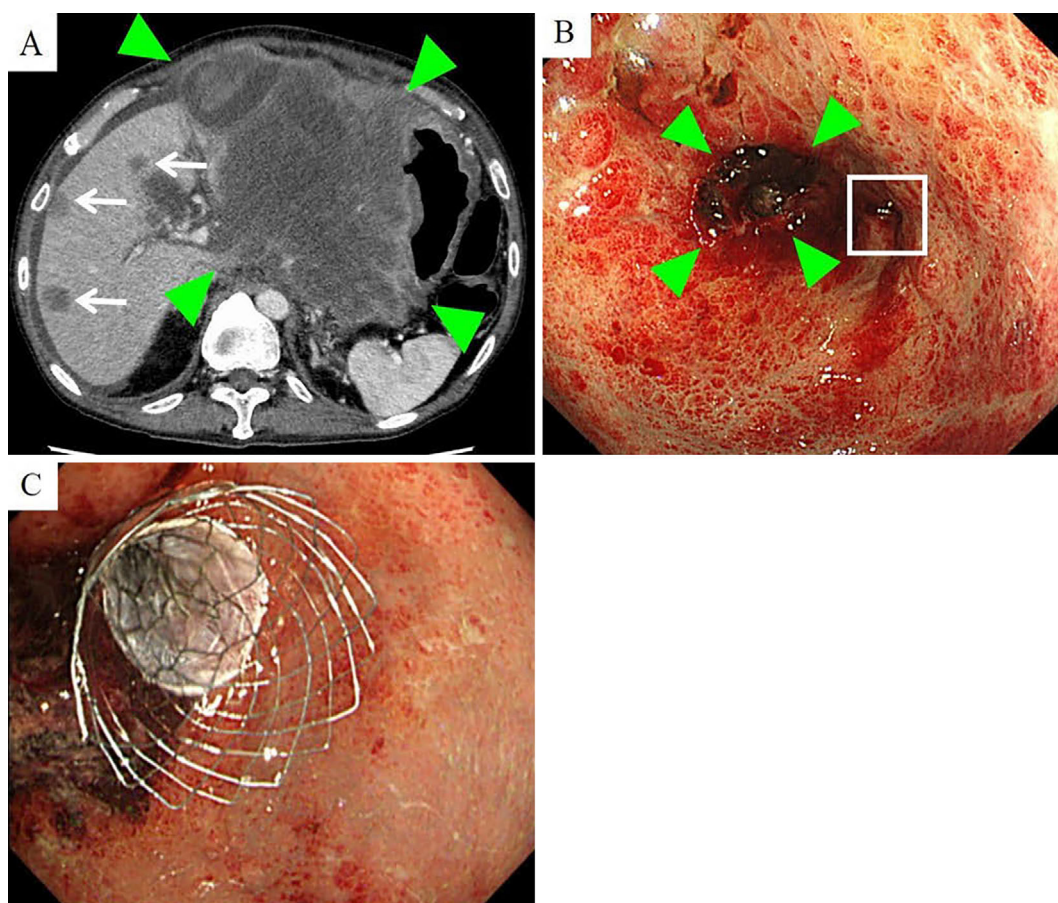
Contrast-enhanced computed tomography images at our hospital on day 56. The pancreatic tumor had grown quickly (arrowheads) and liver metastases were detected (A). Endoscopic examination on day 66 revealed gastric invasion and gastric outlet obstruction (B). A self-expanding metallic stent was inserted through the endoscope and deployed in place (C).
